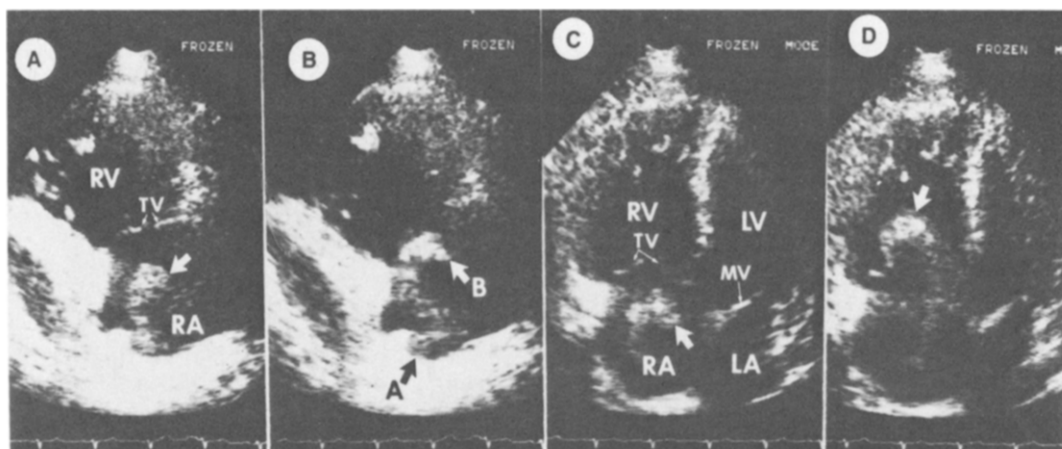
Case 4. Two-dimensional sequential frames of the parasternal long-axis right ventricular inflow tract view. A long, serpentine-like right atrial (RA) thromboembolus (arrow) moves from its coiled position in the posterior portion of the right atrium (A), toward the tricuspid valve (TV) (B,C,D) and into the right ventricle (RV) (E). In F, the thromboembolus twists through the tricuspid valve with its distal end in the right ventricle (top arrow) and its proximal end in the right atrium (bottom arrow).
